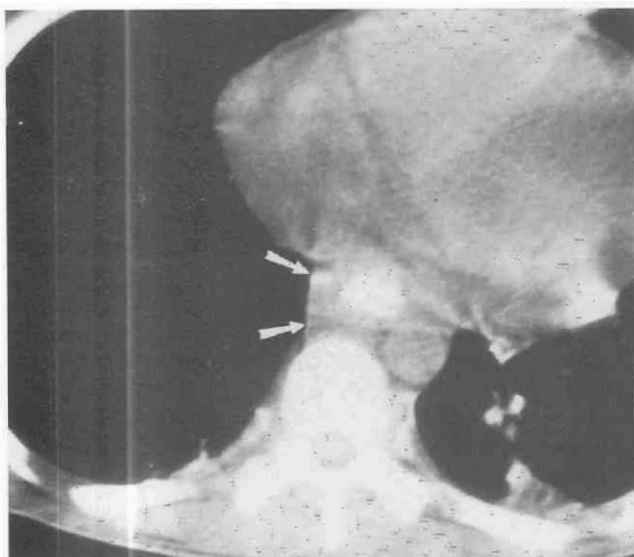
Cytomegaloviral esophagitis. Marked thickening of the esophageal wall is evident on the CT scan. Oral contrast material is retained within the dilated, inflamed esophagus. (From Kuhlman JE: AIDS-related diseases of the chest. In Kuhlman JE [ed]: CT of the Immunocompromised Host. New York, Churchill Livingstone, 1991.)
